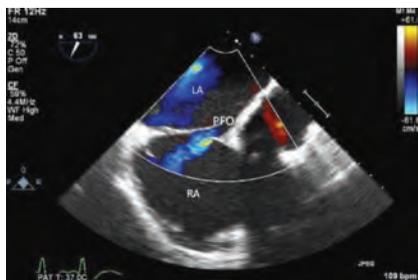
This 2D colored doppler TEE image shows PFO on the interatrial septum.
